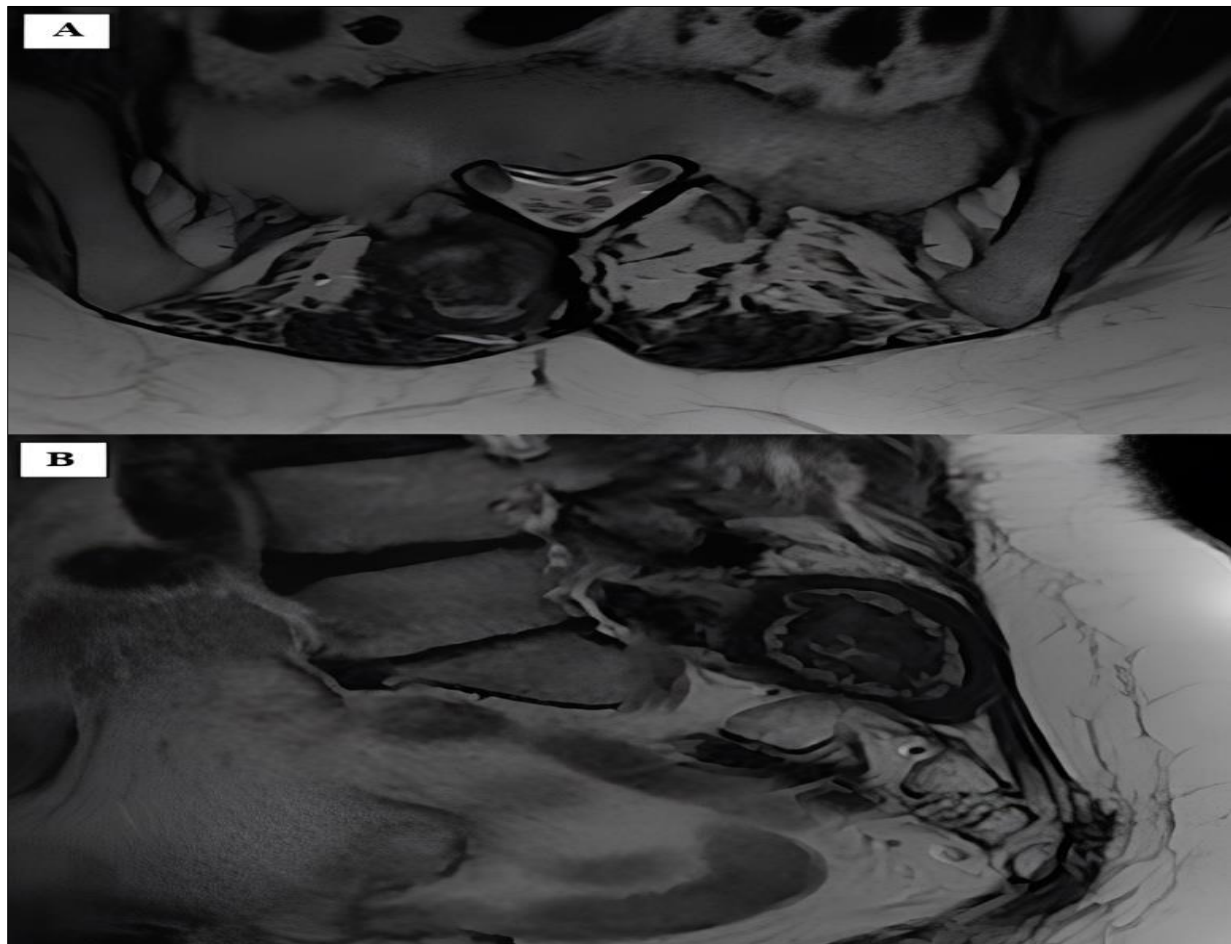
A cystic lesion within the left deep gluteal muscle in the coronal plane (A), in the axial plane (B) at T2-weighted images on MRI.
